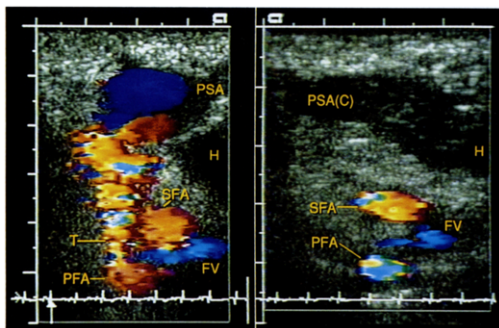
Patient 1. Doppler color flow ultrasonogram in the nonsurgical closure of a femoral artery pseudoaneurysm following percutaneous coronary angioplasty. The superficial (SFA) and profunda (PFA) femoral arteries are shown in cross section. The left panel depicts a long and large tract (T) connecting the profunda femoris artery (PFA) with the pseudoaneurysm (PSA) cavity. A hematoma (H) is present medial to the pseudoaneurysm cavity. The postcompression study (right panel) demonstrates complete obliteration of the connecting tract and absence of flow signals in the pseudoaneurysm cavity, indicating a closed pseudoaneurysm (PSA [C]), which now displays echogenicity identical to that of the previously visualized hematoma. FV = femoral vein.
